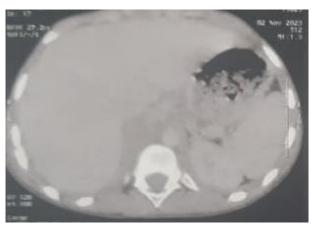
Abdominal CT scan showing a peri-pancreatic edema
